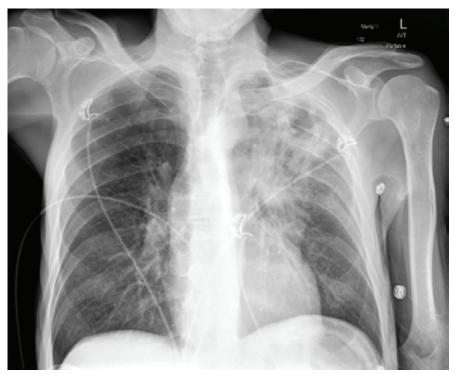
Chest X-ray of a hospitalized patient demonstrating a left upper lobe cavitary lung lesion.
